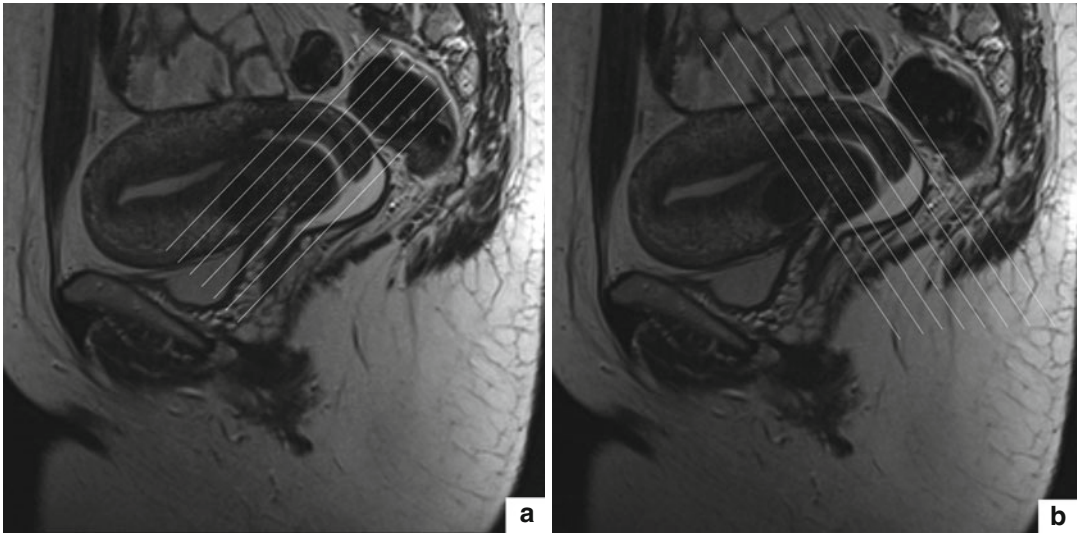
T2w TSE images in sagittal orientation (TR 6,040 ms, TE 90 ms). Example for positioning of the imaging slices in an MRI cervical examination along the short (a) and long (b) axis of the uterine cervix
